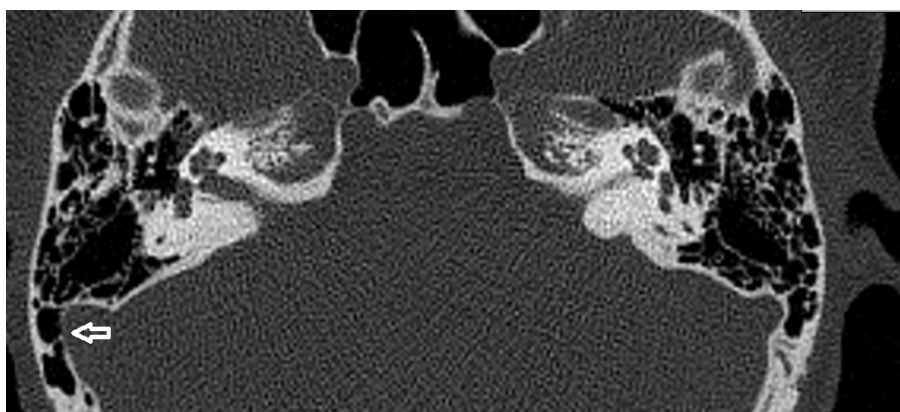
HRCT temporal showing right sigmoid sinus wall dehiscence (white arrow)
